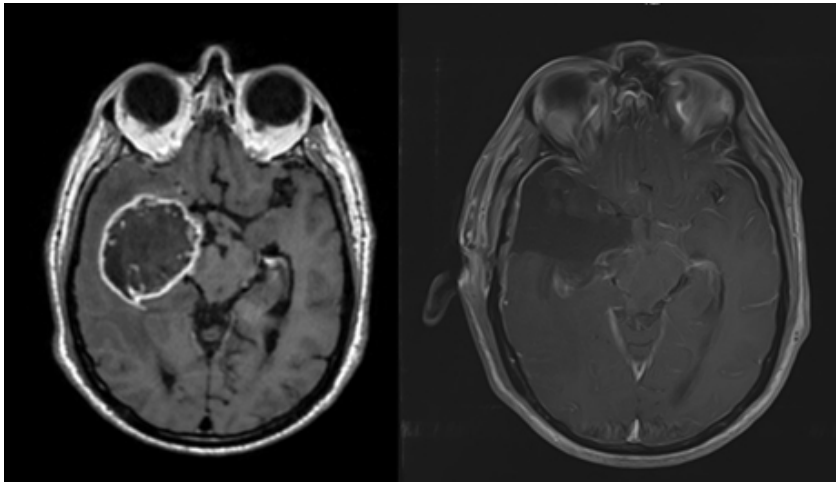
MRI of the brain with contrast Axial view T1+contrast; a: Diagnostic MRI, b: Post-operative MRI within 24 Hours.
